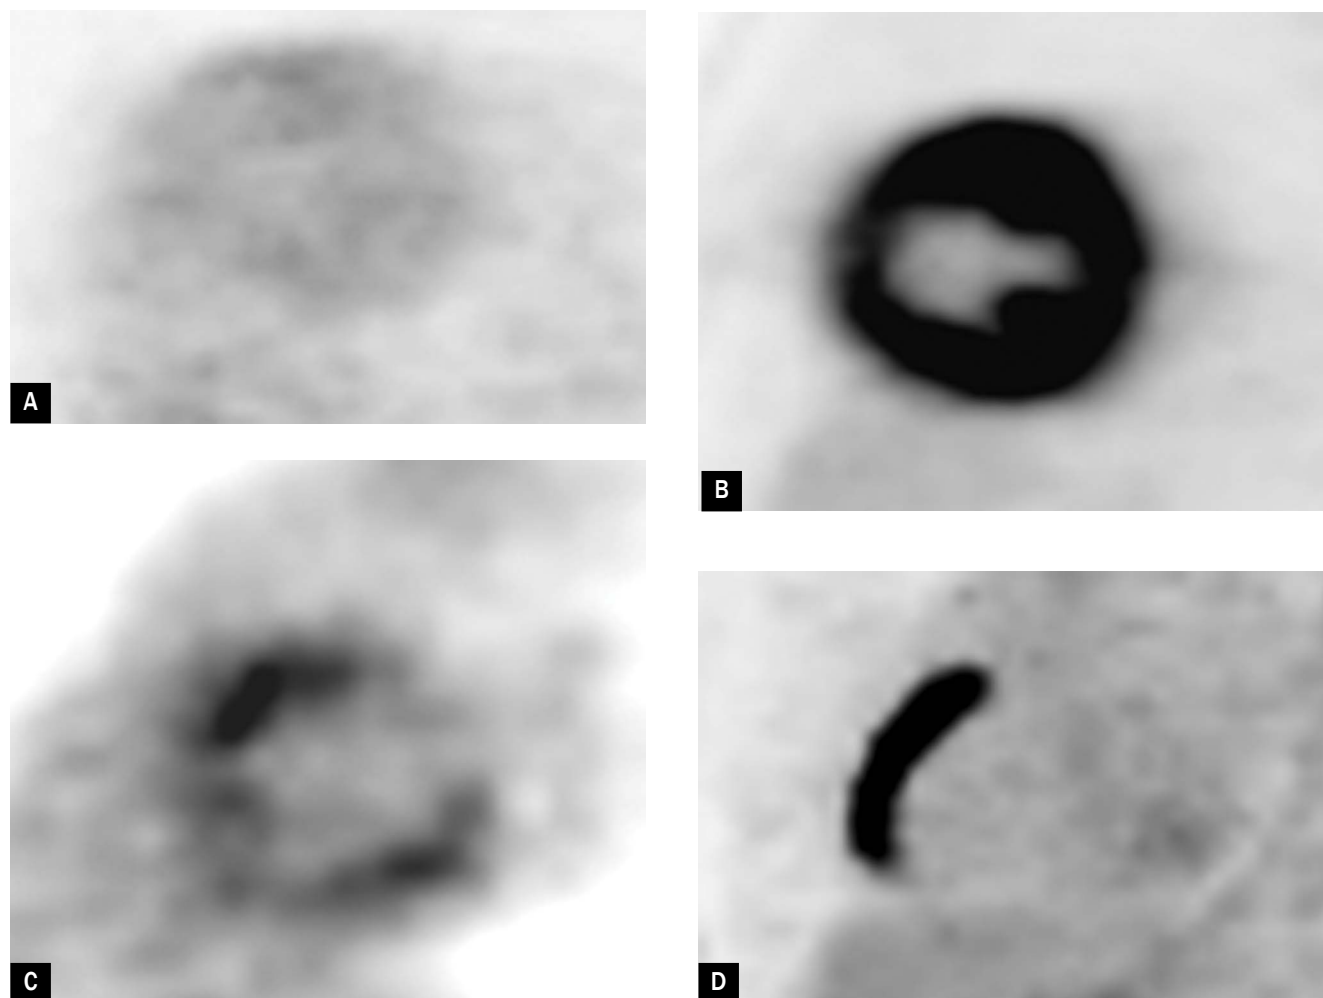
Selected axial [¹⁸F]FDG PET images demonstrating four patterns of myocardial FDG uptake; A. Completely absent myocardial [¹⁸F]FDG uptake; B. Diffuse intense myocardial [¹⁸F]FDG uptake; C. Patchy with focal myocardial [¹⁸F]FDG uptake; D. Regional/focal [¹⁸F]FDG uptake in the septal and anteroseptal wall (arrow)
